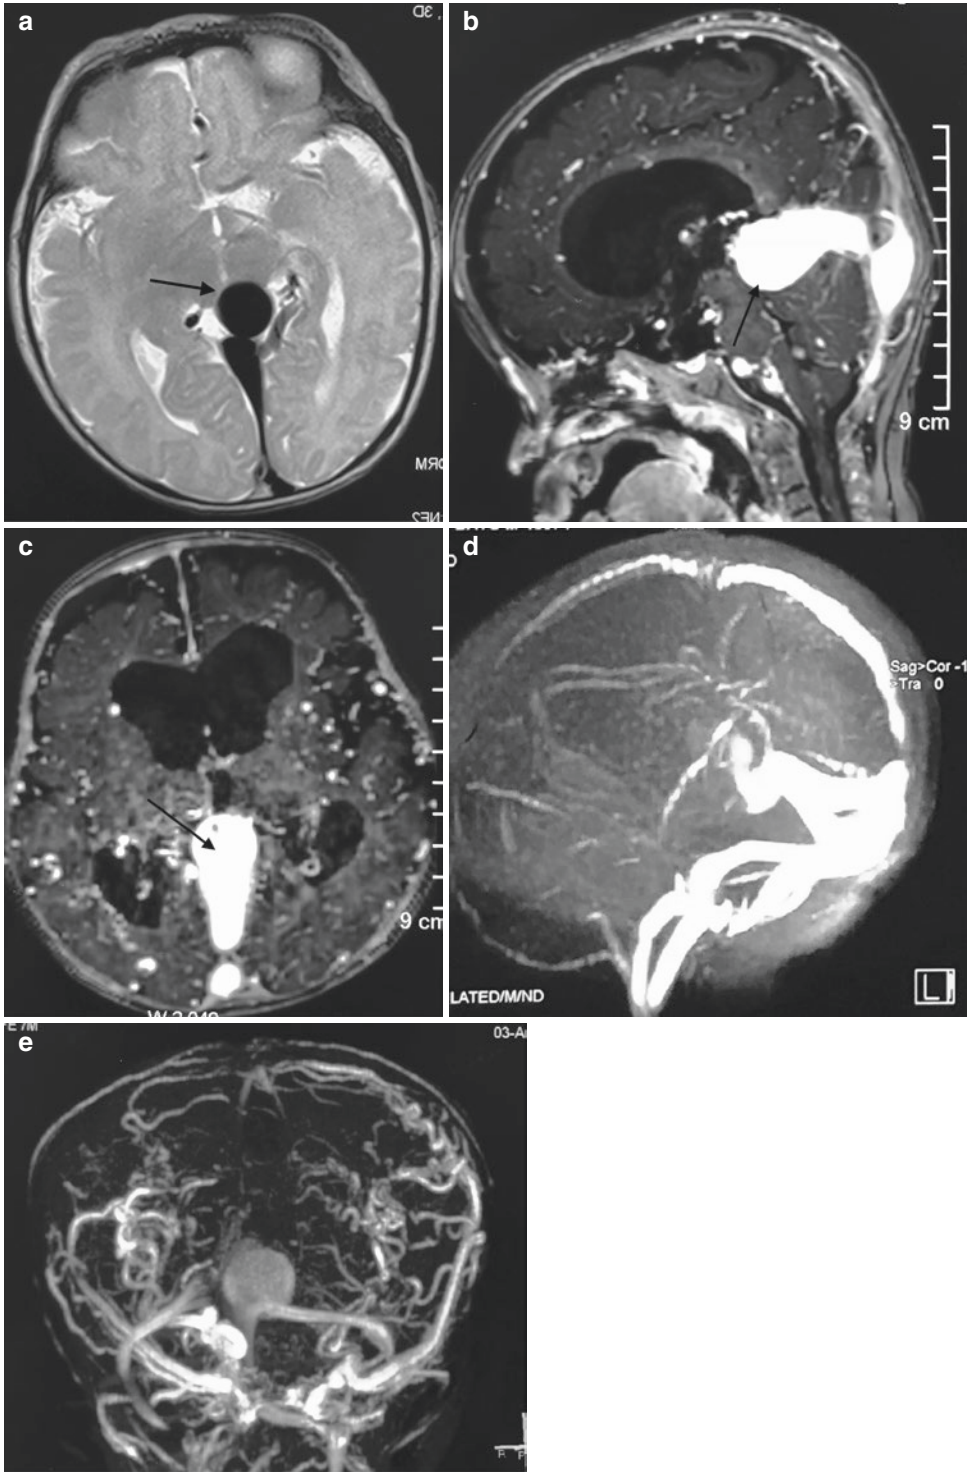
Magnetic resonance imaging of brain. (a) T2-weighted image axial section showing hypointense lesion (VOGM, as shown by arrow). (b) MR angiography
